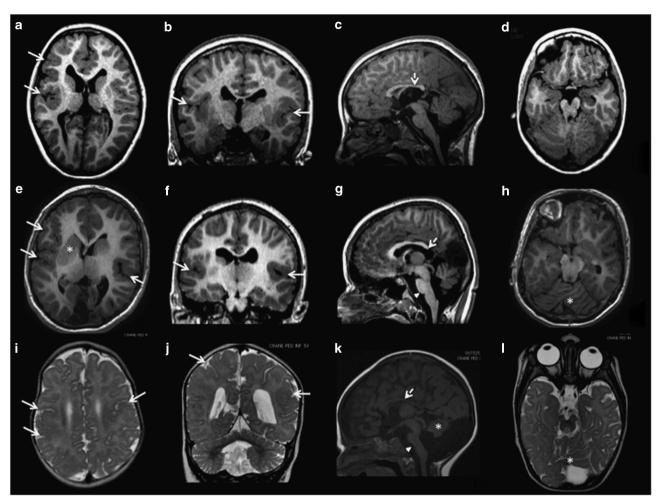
Brain magnetic resonance imaging (MRI) of the three patients with TUBA1A mutations. (a-d) Brain MRI of patient 1 at the age of 5 years; (e-h) brain MRI of patient 2 at the age of 11 years; (i-l) brain MRI of patient 3 at the age of 12 months. This figure shows different aspects of PMG in axial (a, e, i) and coronal (b, f, j) sections. All three patients show asymmetrical PMG that appears more prominent in right perisylvian and frontal regions (arrows in a-f). Associated malformations include mild (arrowhead in (g)) or severe brainstem hypoplasia (arrowhead in (k)), vermian dysplasia (asterisks in (h, k and l)), moderate (dotted arrows in (c and g)) or severe hypoplasia of the corpus callosum (dotted arrows in (k)). The basal ganglia are malformed, appearing as large round structures in which the caudate, putamen and globus pallidus cannot be distinguished (asterisks in (e)).
